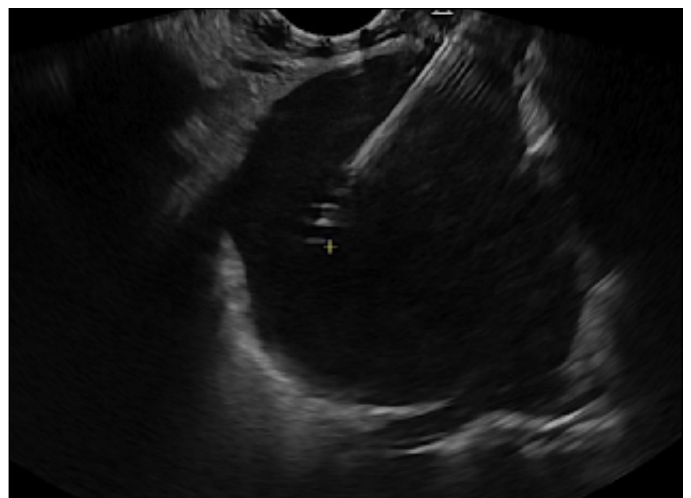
Transesophageal endoscopy ultrasound-guided fine-needle aspiration/biopsy.
